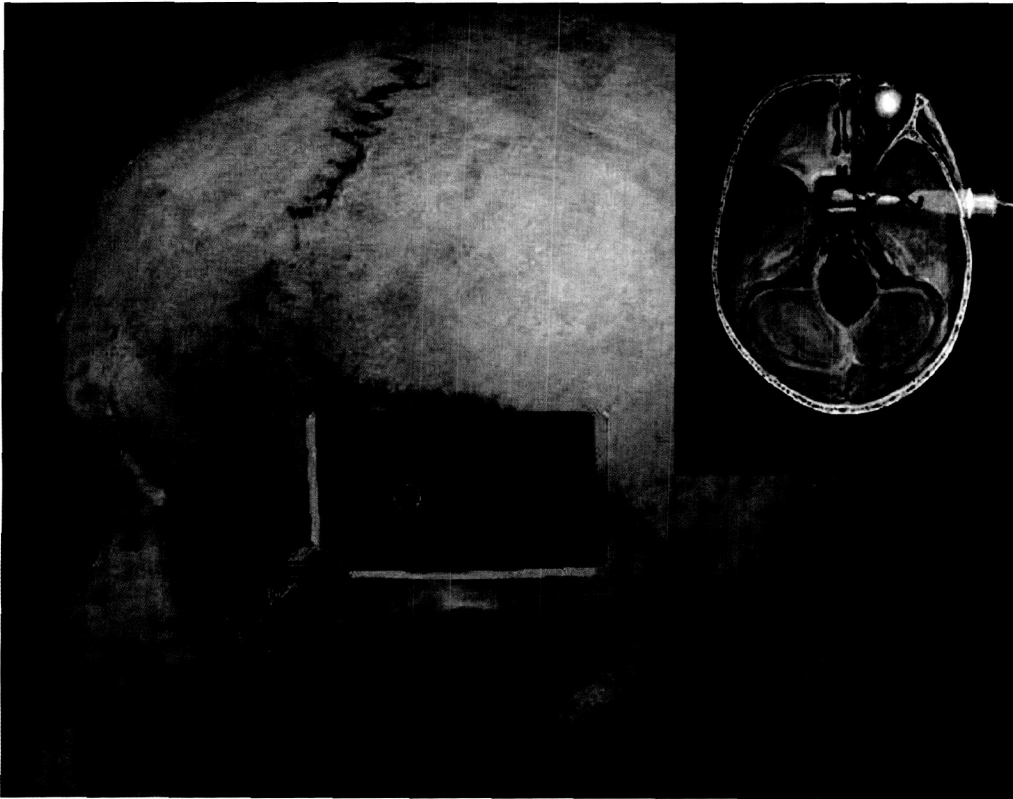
Transcranial Doppler. The middle cerebral arteries head toward the ears. The Doppler ultrasound travels through the skull and is partially reflected back by the blood flowing in the artery. The velocity of blood flow in the middle cerebral artery can be calculated from the reflected ultrasound. Used courtesy of Rune Aaslid.
